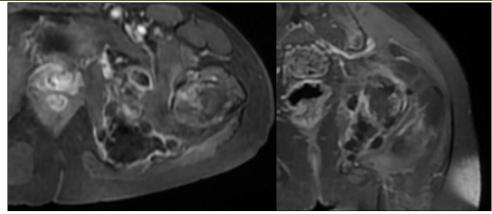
MRI of the pelvis and proximal thighs showing osseous and soft tissue hydatid disease of the left hip (A) Axial STIR image: multiloculated hyperintense cystic lesions involving the left iliac bone, ischium, and femoral head.
